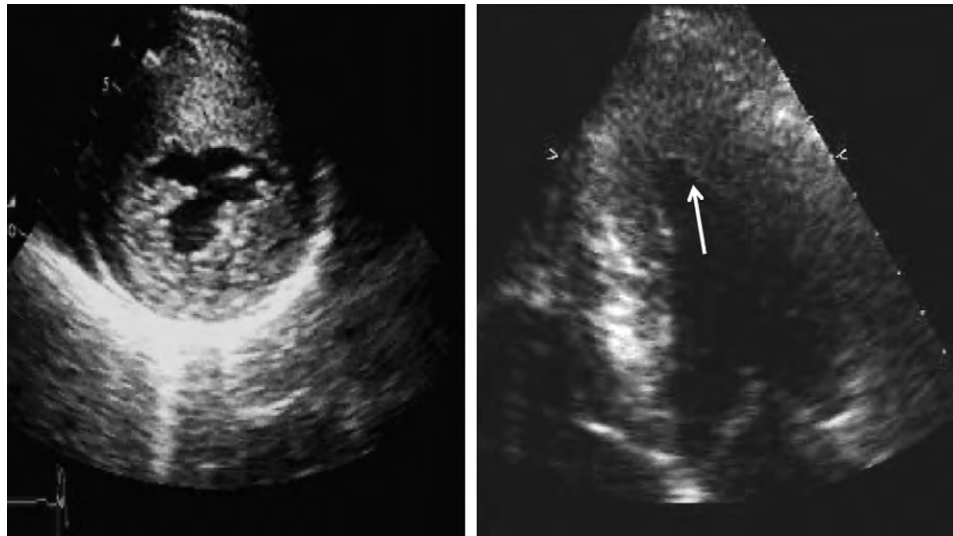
(Left) Parasternal short-axis view from a patient with severe asymmetric HCM involving the anterior septal and anterior lateral walls. (Right) Apical four-chamber view from a patient with apical HCM. The arrow points to the hypertrophy in the distal lateral wall.
